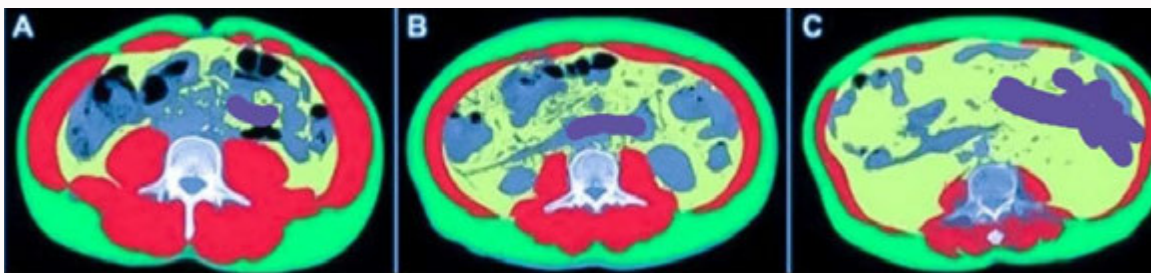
Computed tomographic scans with varying degrees of severity that display body composition in several AP patients. [A-C] Display AP that is mild, moderately severe, and severe, in that order. Dark red represents skeletal muscle, faint yellow represents visceral adipose tissue, and shining green represents subcutaneous adipose tissue. When the degree of AP grew at a comparable BMI, VAT likewise steadily increased (54.01 cm², 135.8 cm², and 372.4 cm²). Conversely, SMA displayed a trend toward decline (52.41 HU, 37.08 HU, and 18.99 HU).
